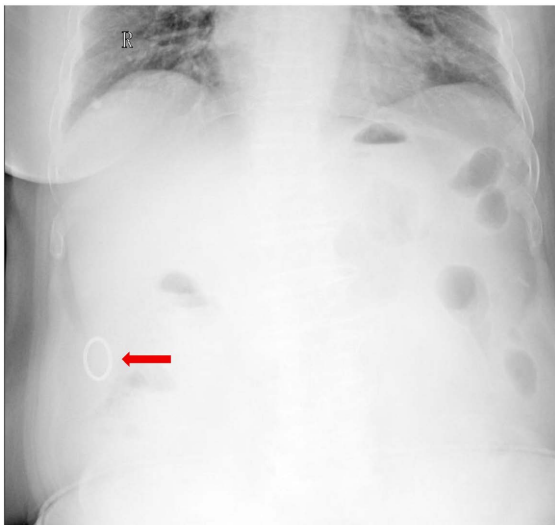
Preoperative chest and abdomen plain film, with IUD marked by arrow
